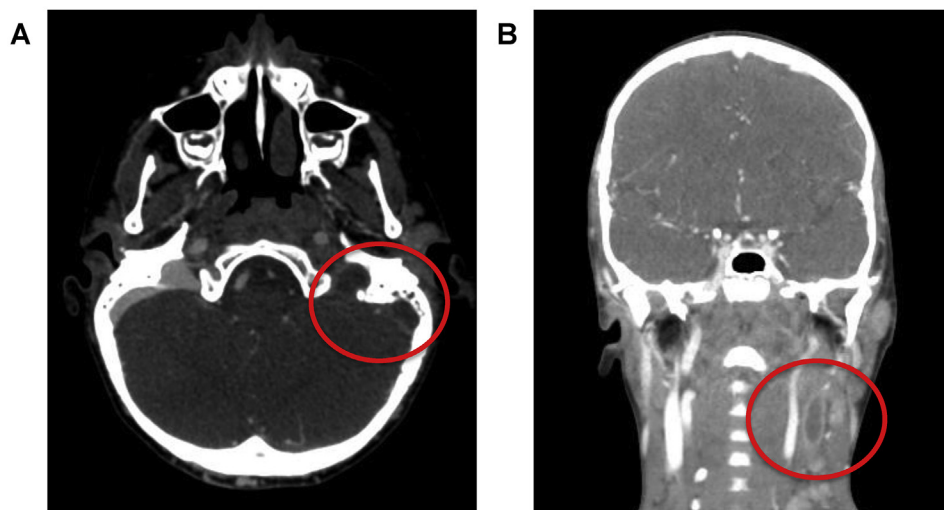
Computed tomography of the neck. Axial radiograph (A) shows absence of contrast in the transverse sinus and jugular foramen consistent with thrombus. Coronal image (B) demonstrates no contrast in the left jugular vein but thickened walls with associated soft tissue swelling and inflammatory changes involving the left sternocleidomastoid muscle.
